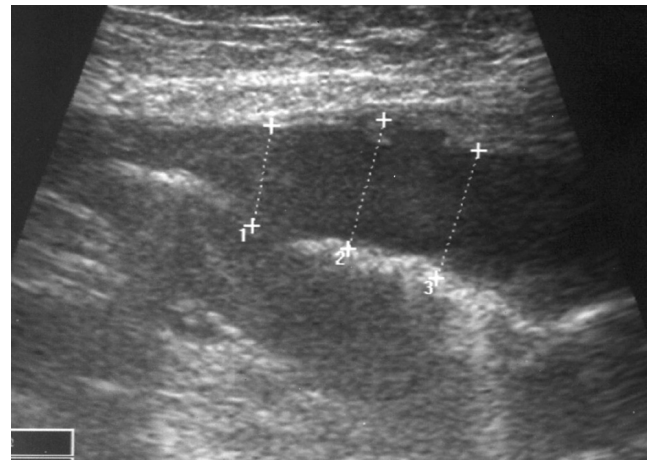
Transabdominal ultrasonography in a patient with gastric cancer. Transverse scan image shows diffuse transmural thickening of the gastric wall (mean thickness, 14.4 mm) with disruption of the stratification of gastric wall.
